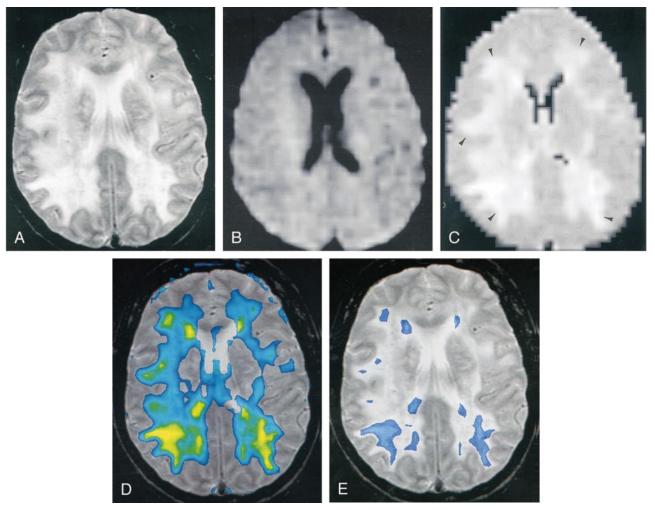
MR imaging of a 32-year-old woman with PRES resulting from severe hypertension. Most severe degree of elevation of ADC values is seen in posterior WM despite relatively diffuse distribution of hyperintense regions on T2-weighted images.
